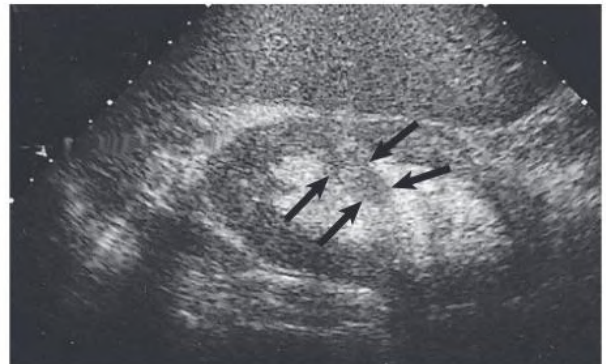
Sagittal Kidney Ultrasound. The column of Berlin (*arrows*) is easily identified because of echotexture similar to that of kidney cortex.
